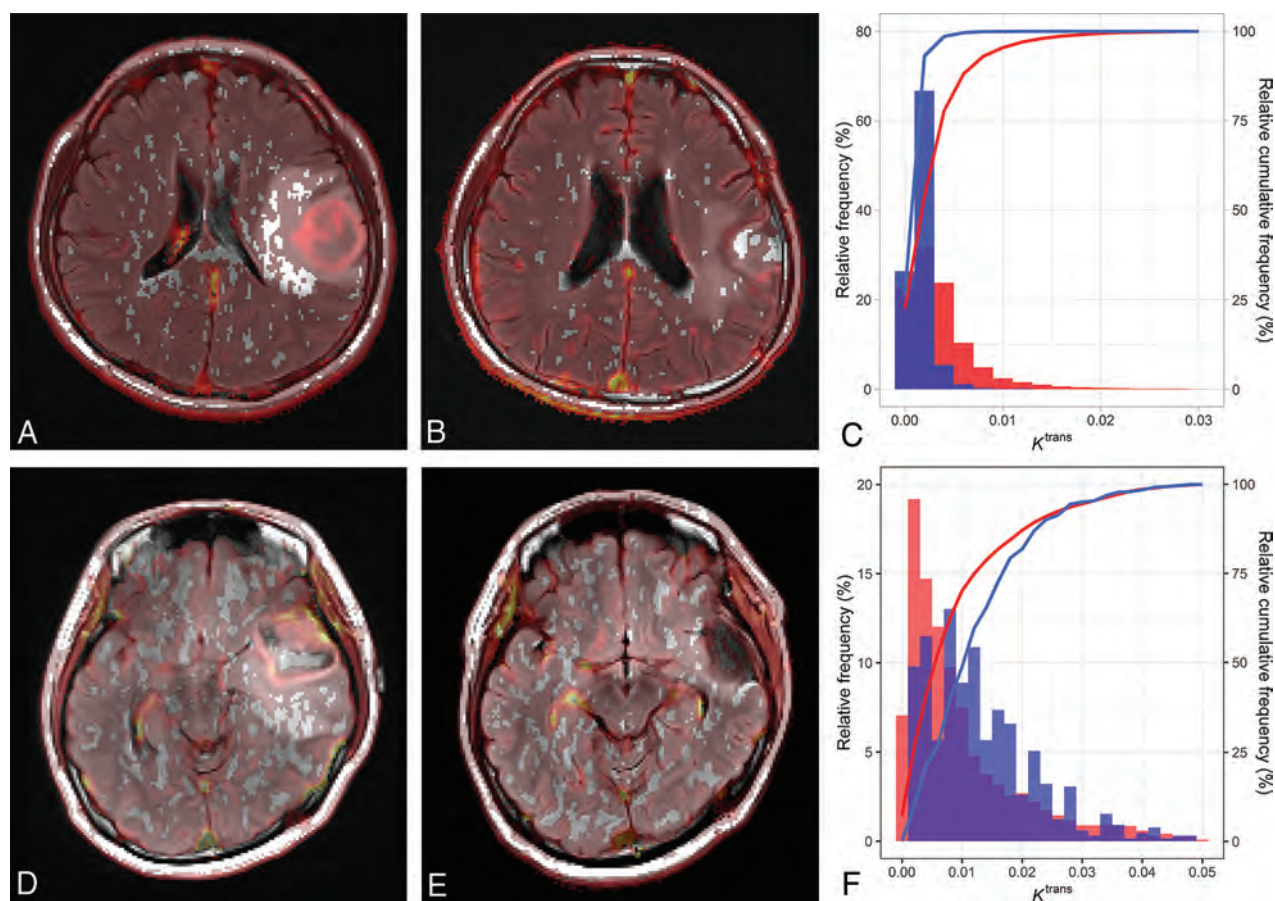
Representative cases. A 54-year-old man who was diagnosed with glioblastoma *IDH* wild-type in the left frontal lobe. Nonenhancing T2 high-signal-intensity lesions around the enhancing mass (postcontrast images are not shown) are noted on baseline FLAIR images with an overlay of the K^{trans} map (A). Posttreatment FLAIR images with an overlay K^{trans} map show residual T2 high-signal-intensity lesions around the surgical margin (B). A cumulative histogram is shown in C. The red bar and line indicate the distribution of the baseline K^{trans} of nonenhancing T2 high-signal-intensity lesions, while the blue bar and line show the distribution of the posttreatment K^{trans} values. The baseline median K^{trans} of nonenhancing T2 high-signal-intensity lesions was 0.00258 min^{-1} . The patient survived 1600 days after the diagnosis without progression. A 42-year-old woman was diagnosed with glioblastoma *IDH* wild-type in the left temporal lobe. Baseline (D) and posttreatment (E) FLAIR images with an overlay of the K^{trans} map show T2 high-signal-intensity lesions around the enhancing tumor (postcontrast images are not shown), partially removed by an operation, but remnant T2 high-signal-intensity lesions are noted. A cumulative histogram is shown in F. The baseline median K^{trans} is 0.00670 min^{-1} . The progression-free survival was 347 days, and the recurrent enhancing tumor developed along the superior-posterior surgical margin on subsequent follow-up MR imaging.
